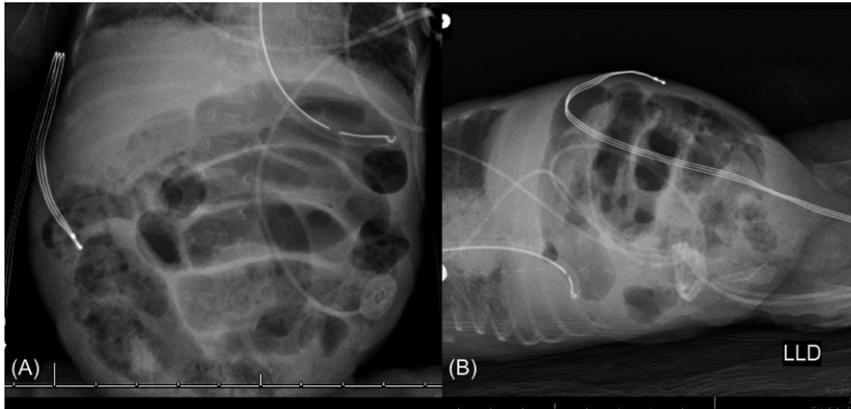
Abdominal radiograph, (A) anterior posterior view and (B) left lateral decubitus, 24 hours after the discontinuation of 12 days of topiramate showing moderate to severely distended and elongated bowel loops with pneumatosis, diagnostic of NEC. LLD, left lateral decubitus.
